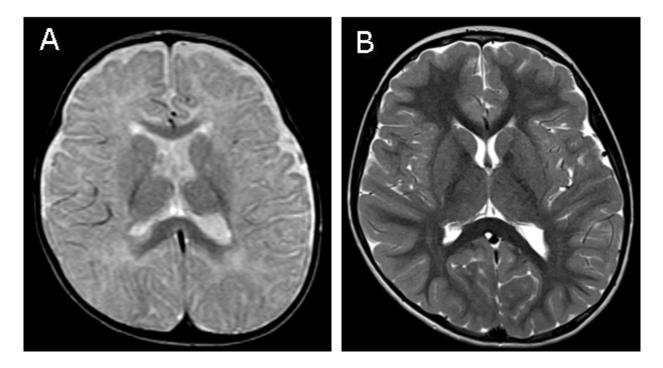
(A) T₂-weighted sequences of the brain MRI of a child age 12 months with AHDS showing diffusely abnormal white matter; (B) same child at age 7 years showing improved myelination with time
